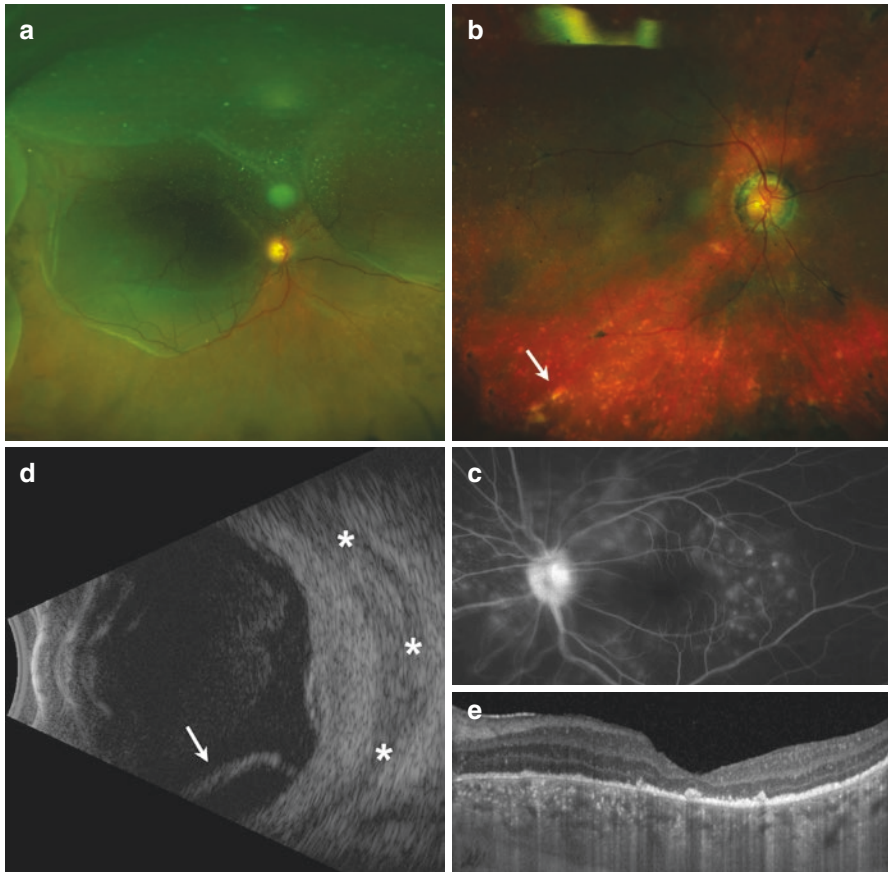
Vogt-Koyanagi-Harada (VKH) syndrome and posterior scleritis. (a) Multifocal exudative retinal detachment in the acute stage of VKH. (b) Pigmentary changes and punched-out chorioretinal lesions (arrow) in a patient with VKH. (c) Fluorescein angiography showing multiple spots of leakage within an area of exudative detachment in VKH. (d) B-scan ultrasound in a case of posterior scleritis showing exudative retinal detachment (arrow), choroidal and scleral thickening and collection of fluid in the subtenons space (asterisks). All of these features other than the subtenons fluid may be seen in VKH. (e) OCT line-scan showing outer retinal loss, hyper-reflective foci, and significant choroidal thickening in VKH
